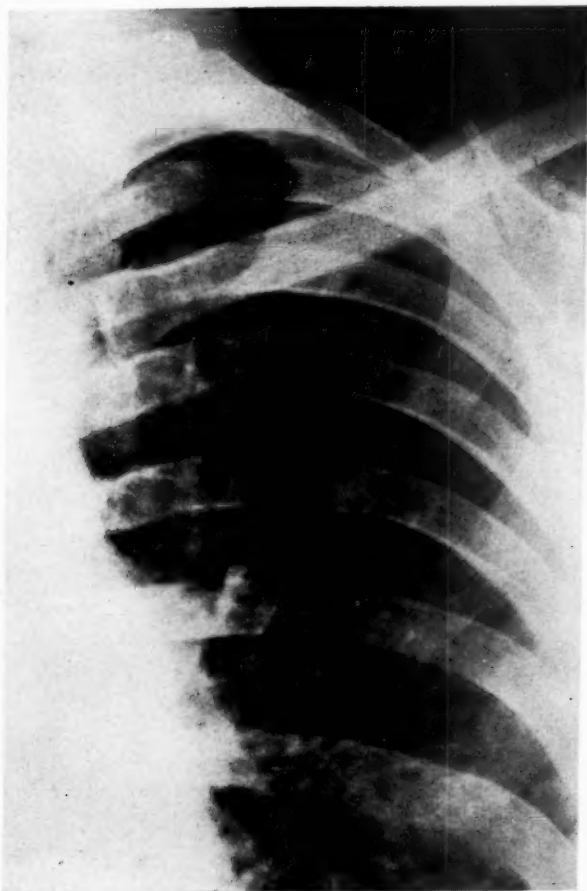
Detail of chest roentgenogram of Oct. 19, 1943, showing the soft mottling with the suggestion of nodulation. The nodulation is thickest near the hilum, and thins out toward the apex and the periphery of the lungs.
